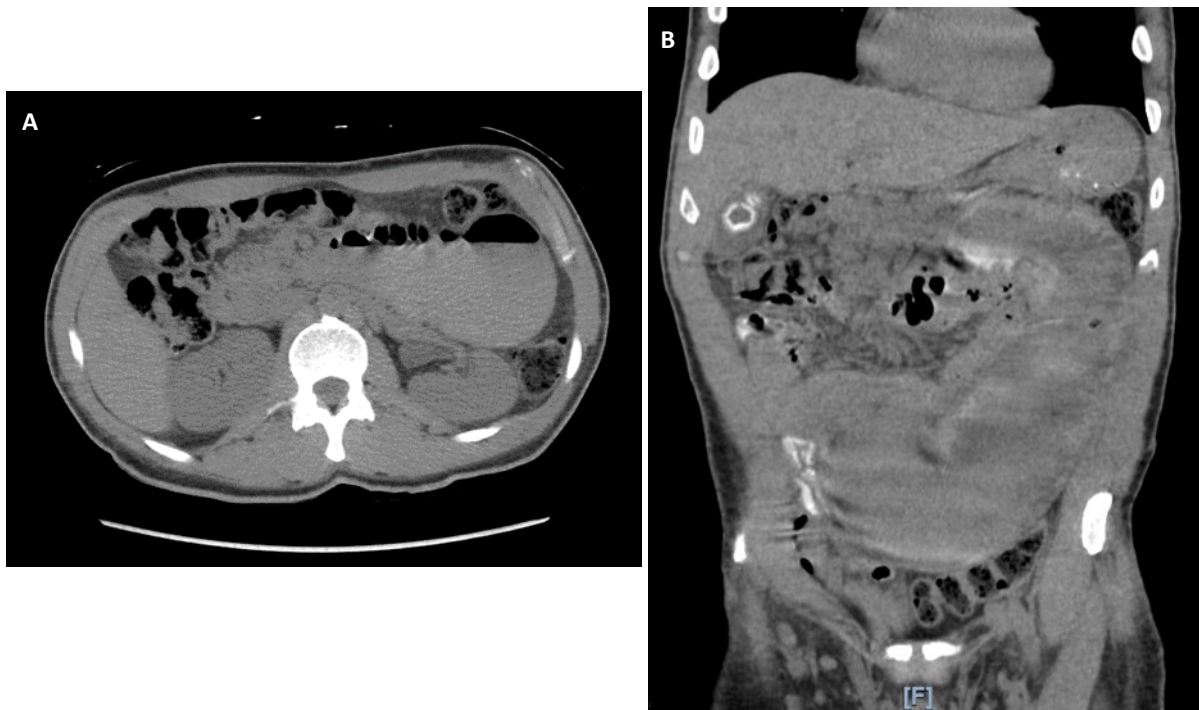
Computed tomography (CT) scan of the abdomen and pelvis with and without IV contrast. (A). Transverse - presence of air-fluid level, SBO (B). Coronal- dilated proximal jejunum.
